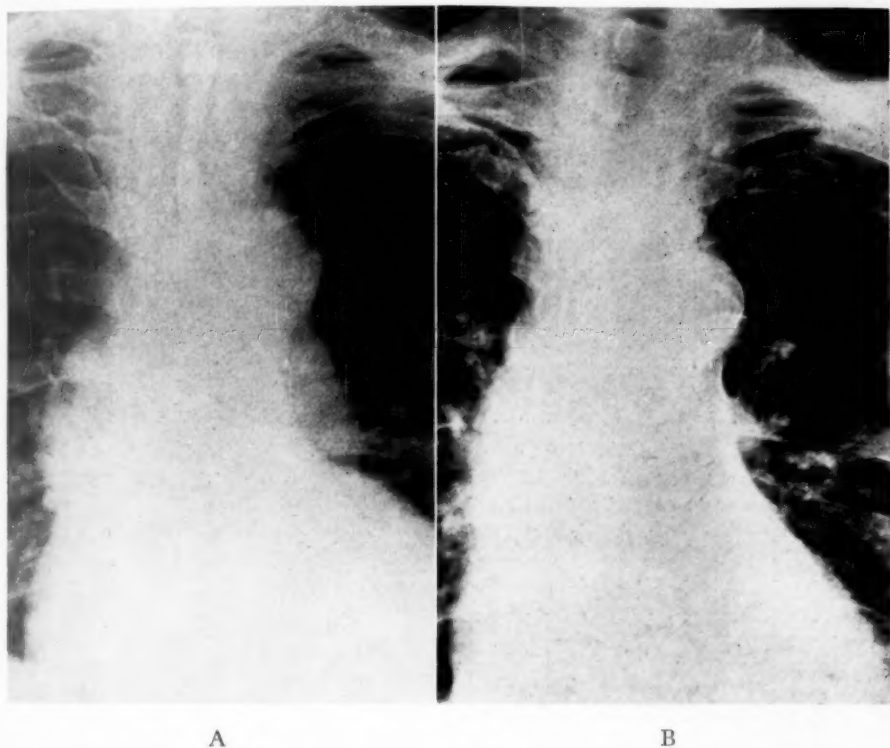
(Case 5)—Roentgenogram of chest. (A.) Preoperative film. (B.) Film ten days after retrograde carotid arteriogram, showing residual Thorotrast in wall of aorta.
